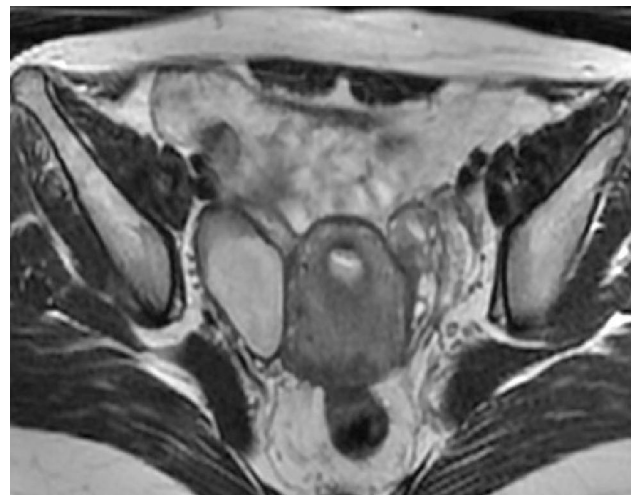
MRI T2 weighted Coronal Image: Large cystic area is seen in right adnexa with high signal intensity on T2 weighted images representing Endometriotic cyst.
